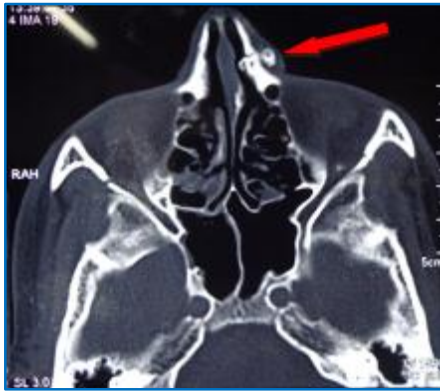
Axial view of CT scan showing the radiopacity
